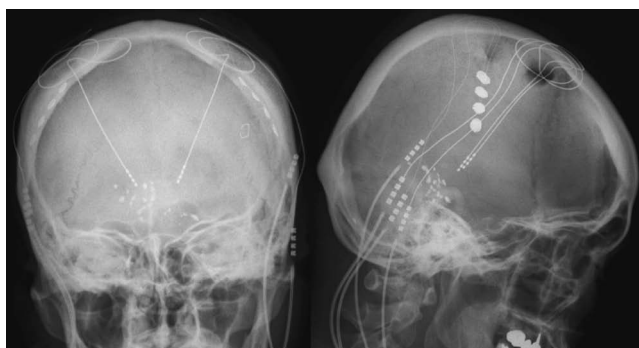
Case 9. Radiographs showing placement of the electrode arrays in the bilateral precentral gyri and deep brain-stimulating electrodes in the bilateral ventrocaudal nuclei of the thalamus.
